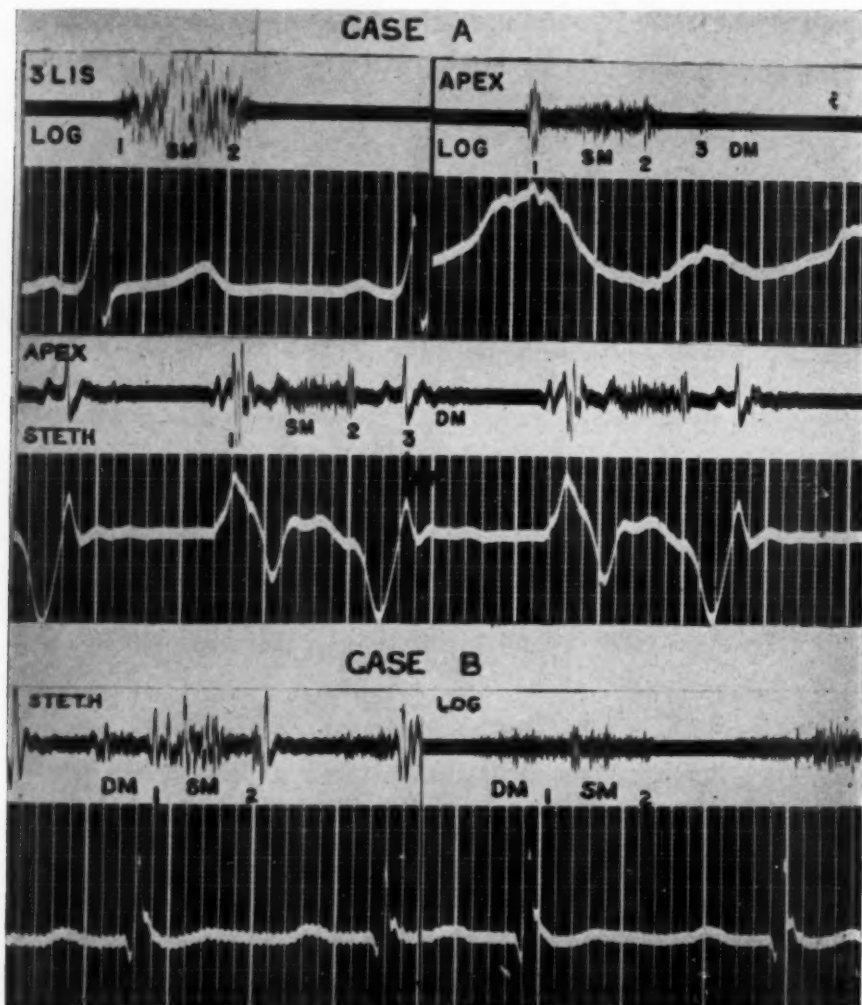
Phonocardiograms in the two proved cases of ventricular septal defect. *A*. The logarithmic records (upper row) show an intense systolic murmur loudest over the third left intercostal space parasternally, and the apical mid-diastolic murmur following the third sound. The stethoscopic record (lower tracing) shows the third sound well registered and coincides with the rapid-filling wave (*rf*) of the apex cardiogram. *B*. Stethoscopic and logarithmic phonocardiograms over the apex with the same systolic murmur as in *A* but with the diastolic murmur starting later in diastole and extending into presystole.
